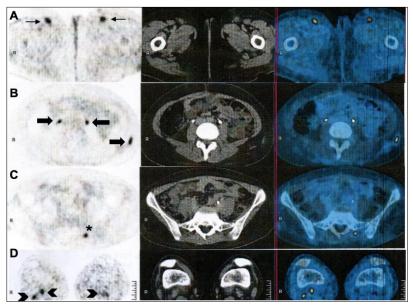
FDG-PET image of the (A) abdomen shows prominent-sized lymph nodes seen in the left inguinal/proximal thigh region, measuring 0.9 cm. Smaller lymph nodes are also seen in both inguinal regions. There is increased FDG uptake in the prominent left inguinal and small bilateral inguinal lymph nodes (thin arrows). (B) Musculoskeletal, FDG-avid diffuse subcutaneous thickening, haziness, and stranding densities in the left upper arm, right epigastric, bilateral posterolateral lumbar region, both pelvic, both gluteal, and both lower extremities (thick arrows). (C) A focus of increased FDG uptake is also noted in the left paraspinal (sacral) muscle, likely an intramuscular node (asterisk). (D) Another FDG-avid focus is noted in the proximal tibia and a smaller focus in the left proximal tibia. FDG-avid bilateral popliteal nodes are also noted, more prominent on the right (arrow heads).
